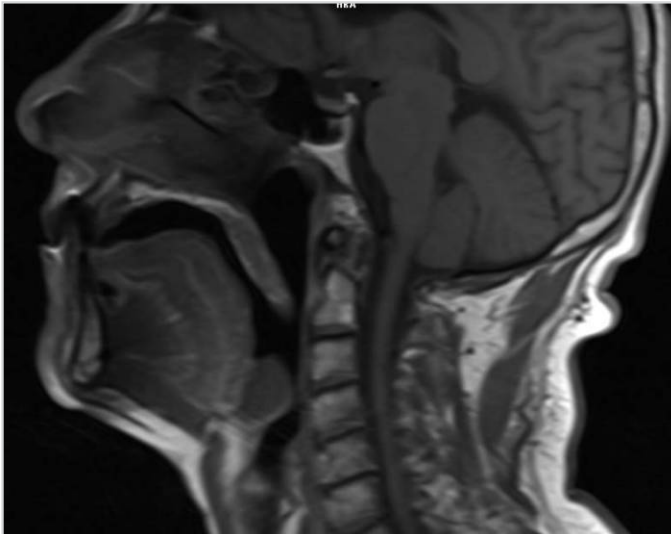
In the section of pre-contrast sagittal T1-weighted MRI, a mass originating from the epiglottis, which causes airway obstruction, is observed.
